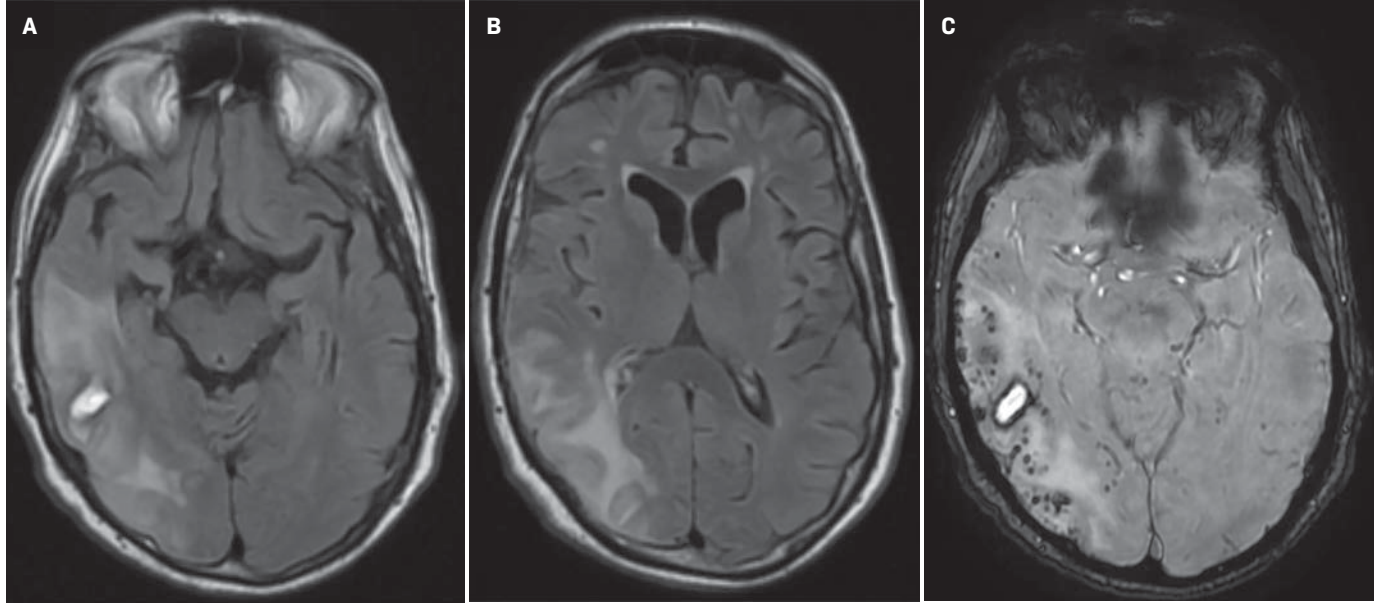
(A, B) Follow-up axial T2 FLAIR demonstrates showing persistence of the temporoparietal hyperintensities. (C) Axial susceptibility-weighted imaging demonstrates interval development of numerous punctate areas of signal loss, consistent with microhemorrhages.
